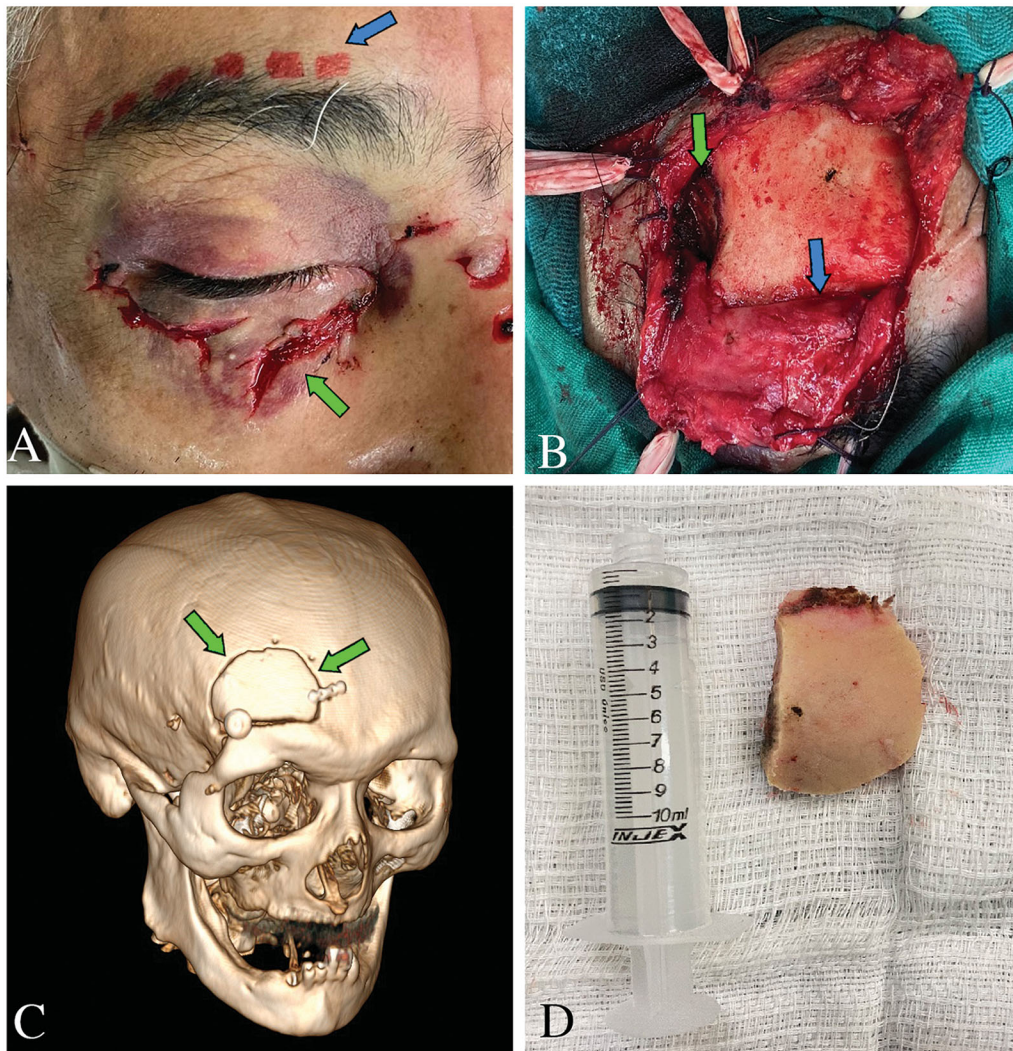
Supraorbital approach. (A) Preoperative incision planning (blue arrow) and aspect of the eye, presenting multiple lacerations, including the one containing the foreign body (green arrow). (B) After skin retraction, the lateral border of the frontal bone exposed (blue arrow), as well as the anterior part of the temporalis muscle (green arrow). (C) 3D volumetric reconstruction of the post-operative CT scan, showing the supraorbital craniotomy (green arrows) after cranioplasty. (D) Frontal bone flap, when compared in size to a 10 mL syringe.
